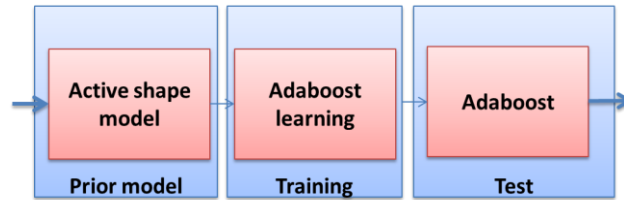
Block scheme for segmentation in t-MRI using the strategy proposed in [75].
